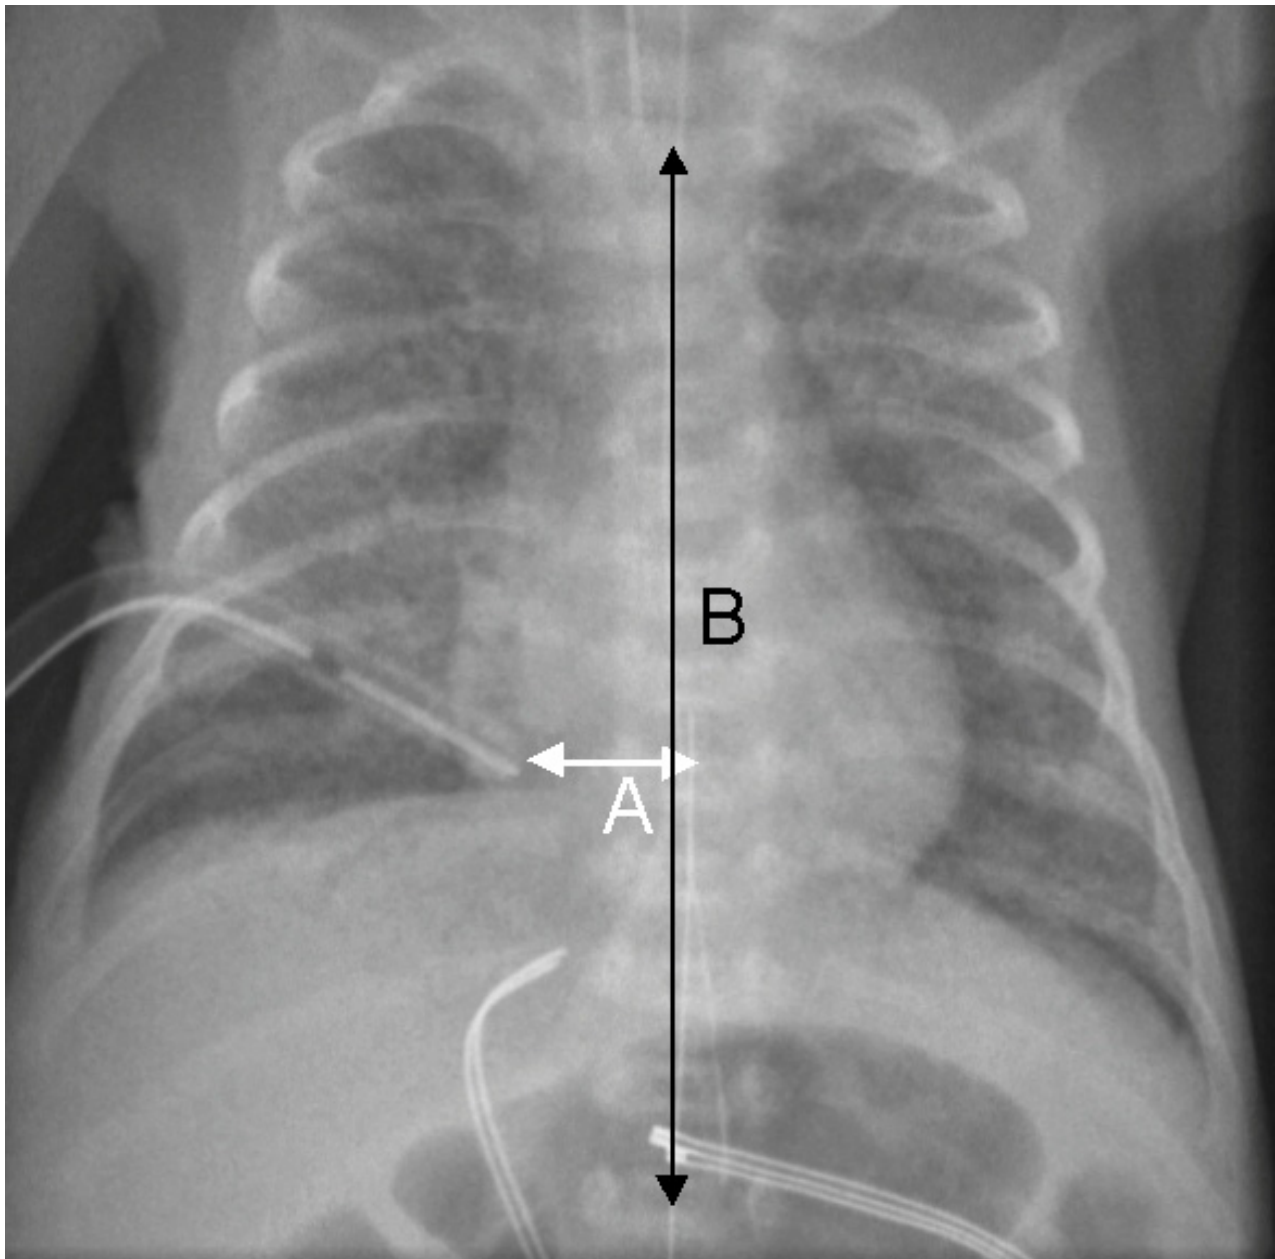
A chest X-ray of an infant with an inter-costal catheter in situ. Measurement A is the tip to midline distance. Measurement B is the distance from the middle of the first to the middle of the last thoracic vertebrae.
